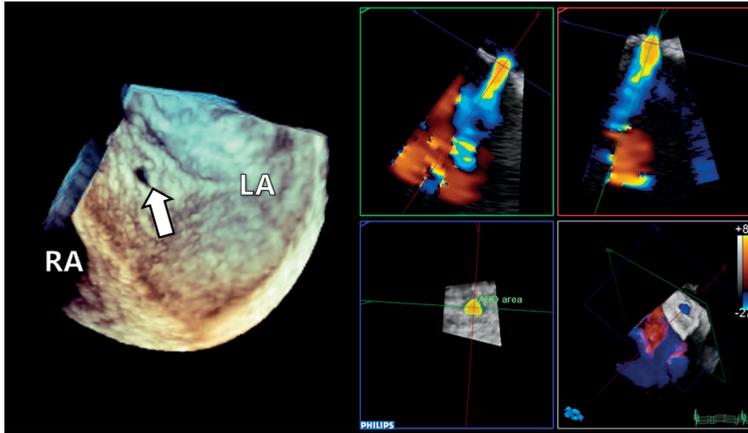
3D view of iatrogenic atrial septum defect (left) and display of shunt using color Doppler (right)
